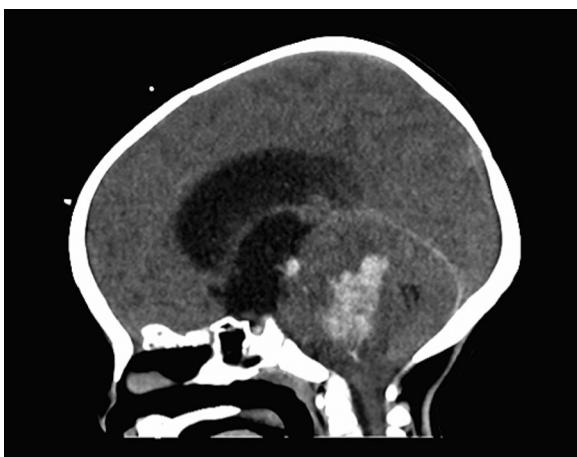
Sagittal CT head demonstrating a large, hemorrhagic posterior fossa mass filling the fourth ventricle with associated hydrocephalus and brainstem compression.
